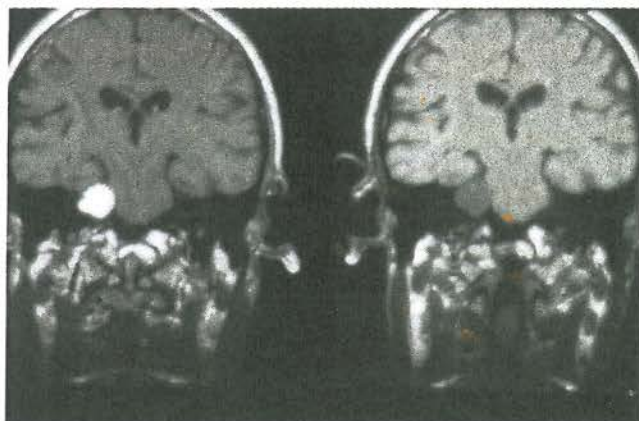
Coronal T1-weighted MRI scan showing a right acoustic neuroma. Before enhancement (right) and after enhancement with gadolinium (left)
